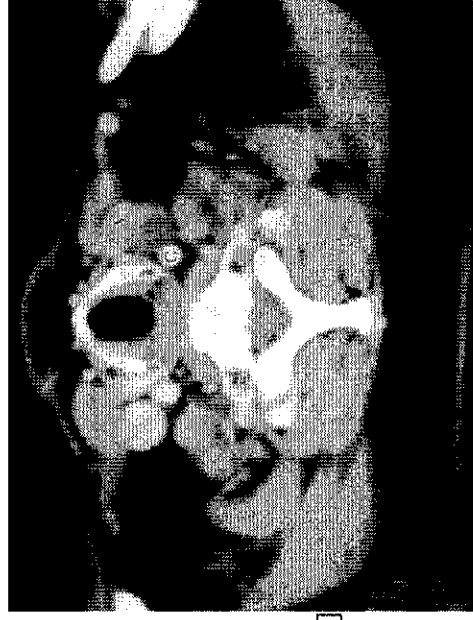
Computed tomographic scan of the parathyroid adenoma. A = parathyroid adenoma inside the vagus nerve; C = carotid artery; V = jugular vein.
